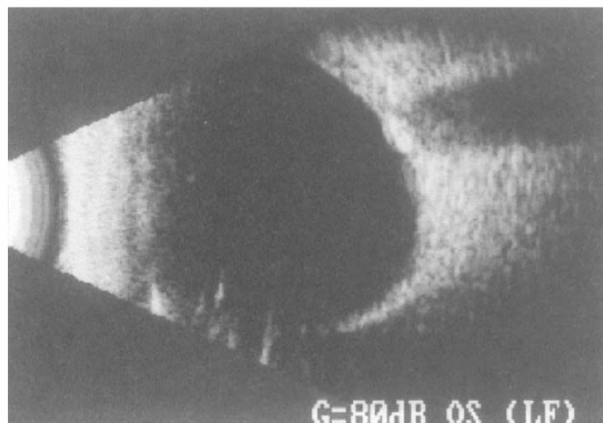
B-scan ultrasonography demonstrating disc drusen at the optic nerve head.
